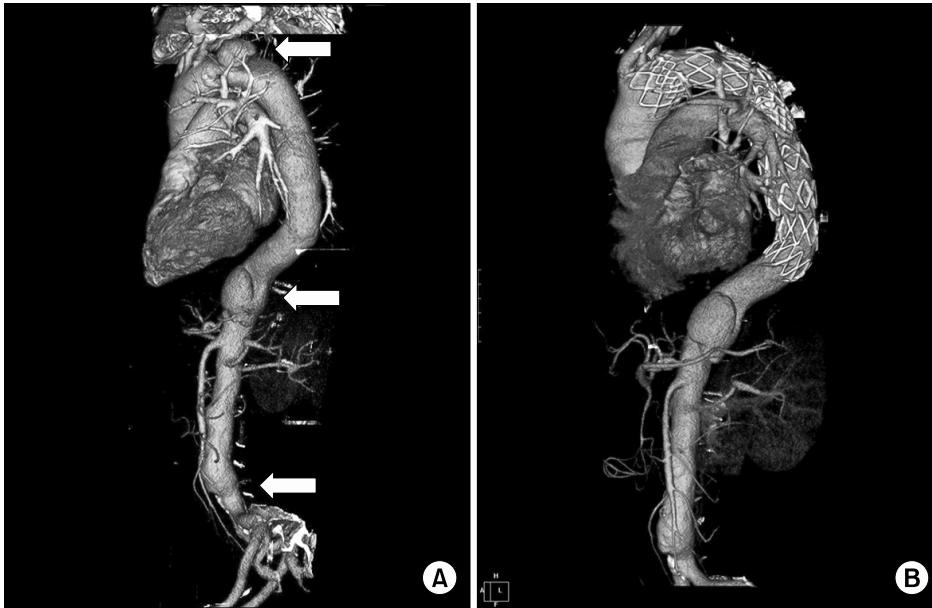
(A) Preoperative three-dimensional reconstructed computed tomography (CT) image showing the multiple aneurysmal dilatations (arrows) in the aortic arch, proximal abdominal aorta, and distal abdominal aorta just above the iliac bifurcation, and (B) post-stent CT image.
